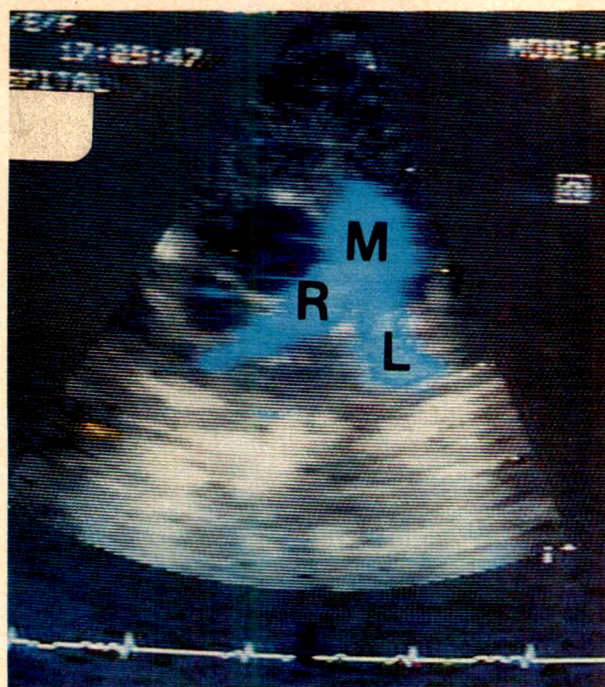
The 2-dimensional color echocardiogram was recorded from a normal neonate during late ventricular systole and displays a uniform flow velocity in both the main (M) and branch right and left (R and L) pulmonary arteries.
